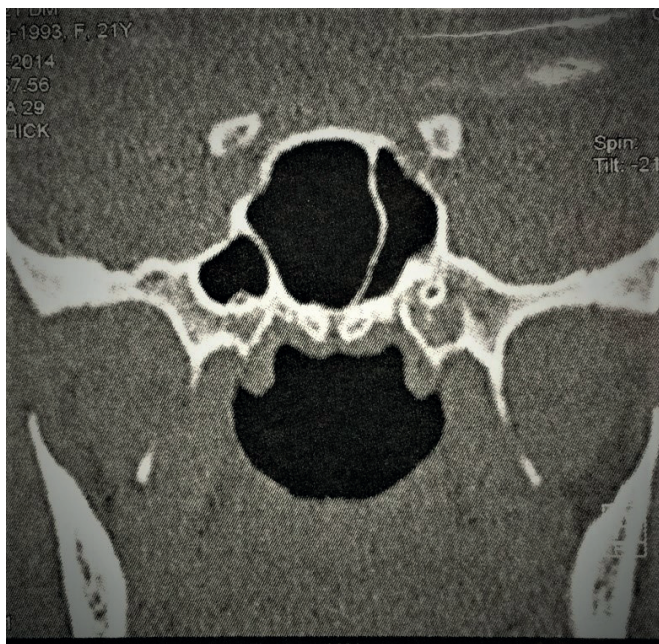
A coronal CT image of an Onodi cell
